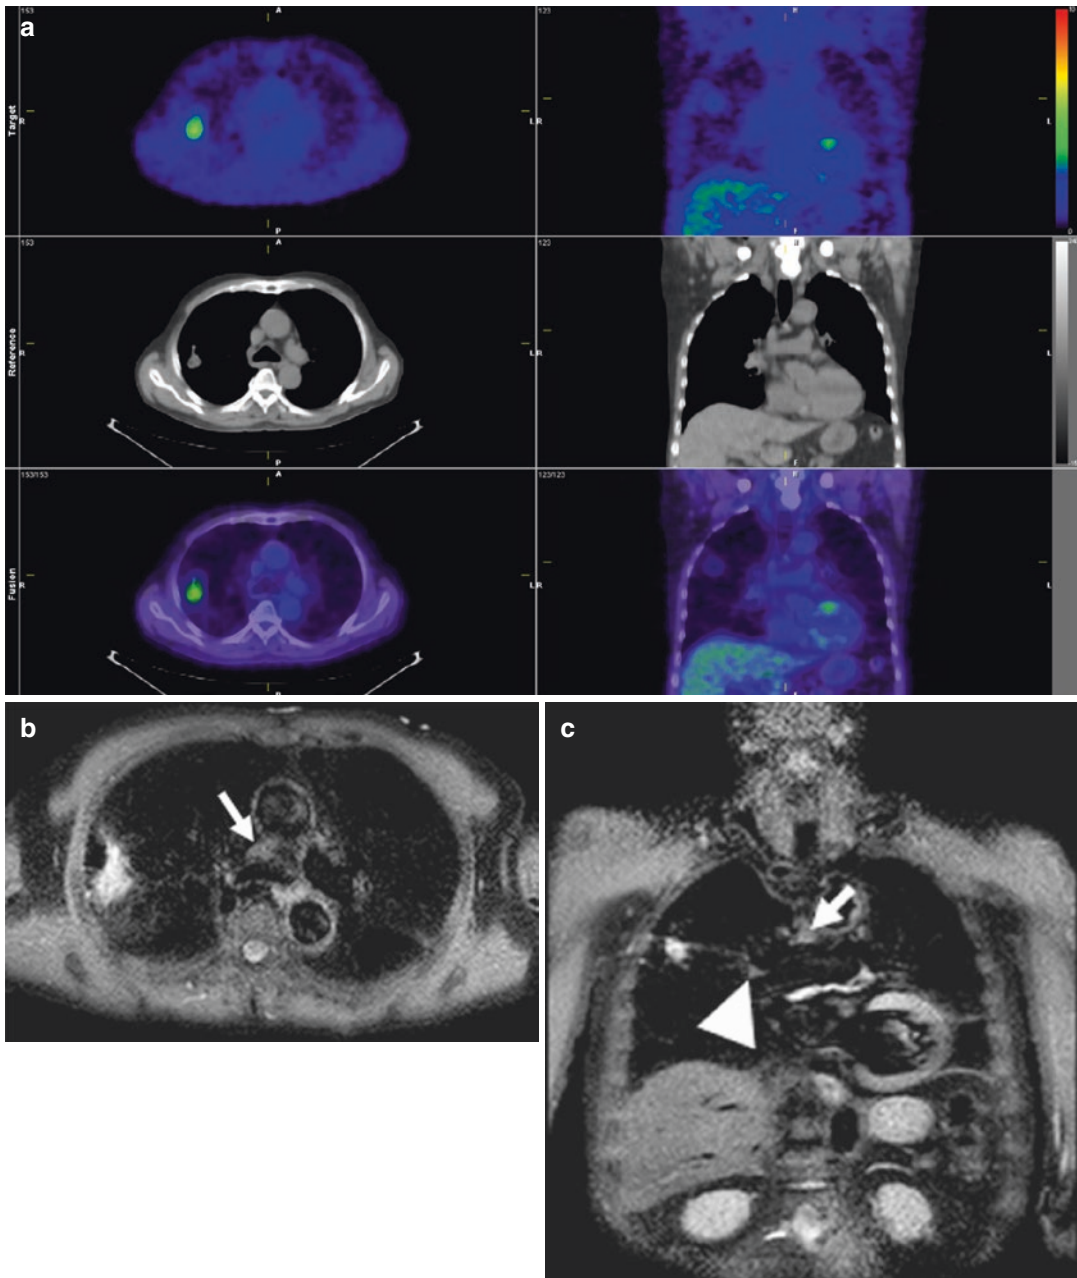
A 77-year-old male with adenocarcinoma (N0). Integrated FDG-PET/CT (a) demonstrates high uptake of FDG in primary tumor, but no uptake in mediastinal and hilar lymph nodes, suggesting N0. Black-blood STIR
